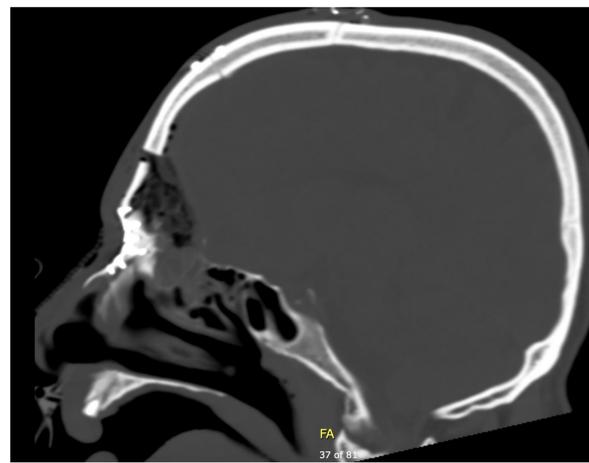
Postoperative CT demonstrating skull base reconstruction and fracture fixation
